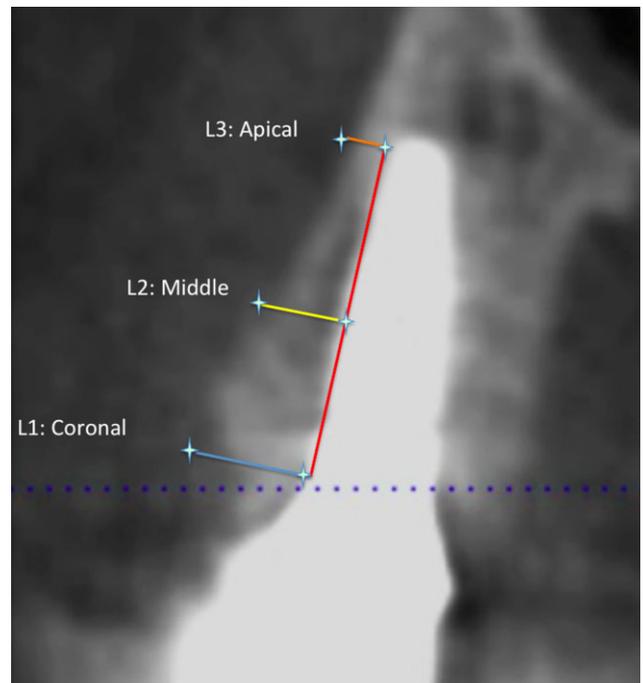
Six to nine months posthealing, CBCT shows radiographic reestablishment of the buccal bone plate and the corresponding measurements.
